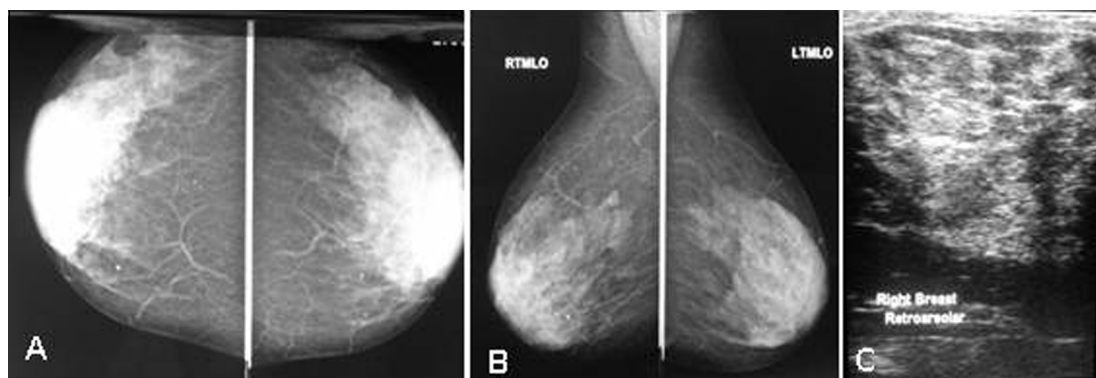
44-y old female presented with mastalgia of the right breast. (A) & (B) Mammographic images (CC & MLO) revealed breast density of ACR 3 with bilateral retro-areolar fullness. (C) Ultrasonographic image of the right breast excluded any underlying hidden solid or cystic lesions, categorized as BI-RADS 1.
